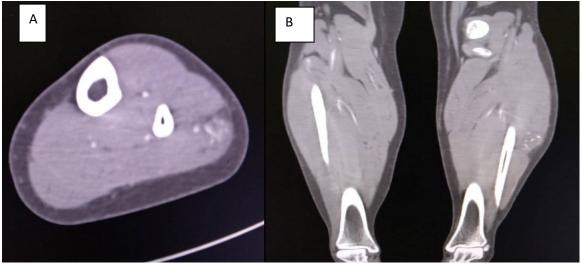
(CT angiography of left lower limb): A & B images show increased vascularity with multiple irregular tortuous vessels of different sizes which include both arterial and venous circulation filling simultaneously with soft tissue swelling postero-lateral aspect of mid third of left leg
